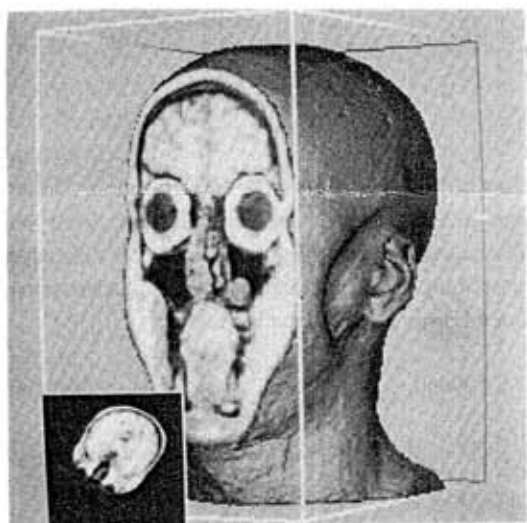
Combined presentation of a surface and cross-sectional information of a head in MRI. (Material: 128 slices, 256x256).
